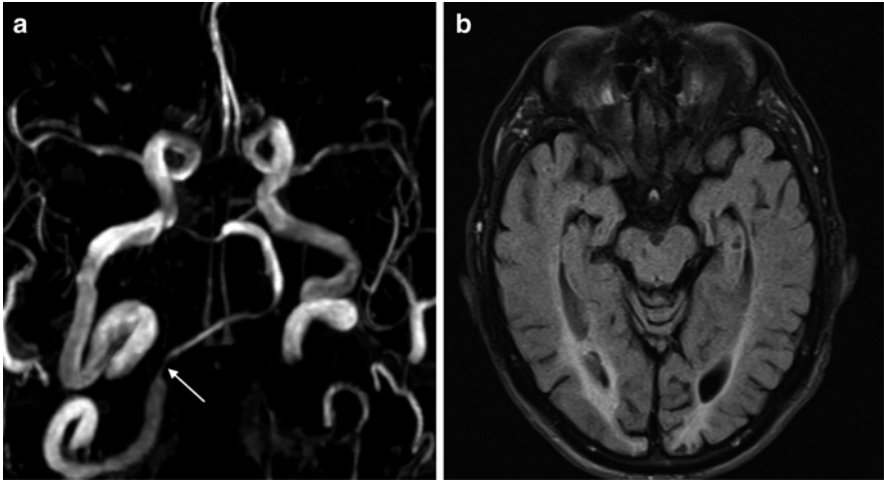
Vertebral artery stenosis. (a) Oblique MIP image from TOF MRA shows severe stenosis of the right intracranial VA (*arrow*). The left VA (not shown) is hypoplastic. (b) Axial FLAIR image shows bilateral infarction of the medial occipital lobes
